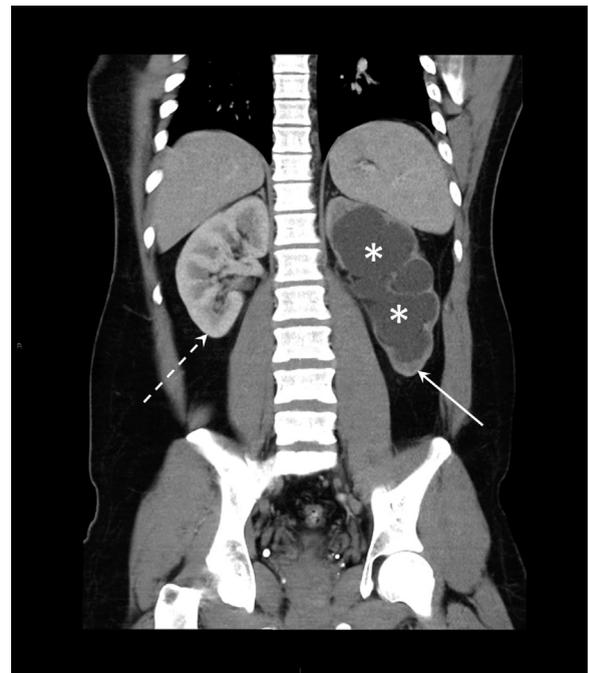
Computed tomography of the abdomen and pelvis (coronal view) demonstrating severe left hydronephrosis (asterisk). Also shown is asymmetric contrast enhancement of the kidneys with delayed uptake of contrast in the hydro-nephrotic kidney (solid arrow) relative to the normal right kidney (dashed arrow).
